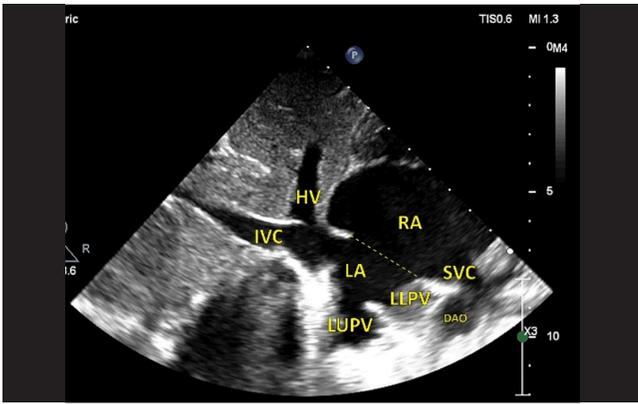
This subcostal echocardiogram depicts the normal drainage of the left-sided pulmonary veins and the drainage of the inferior vena cava and hepatic veins into the left atrium. The dotted line indicates the large atrial septal defect.
